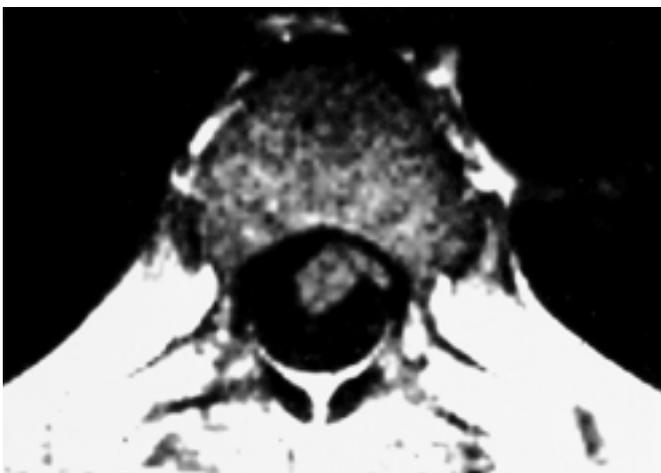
Axial T1-weighted (A) and T2-weighted (B) MR images show left ventrolateral transdural herniation of the spinal cord. Note tongue-like projection of the spinal cord through ventrolateral dural defect.
